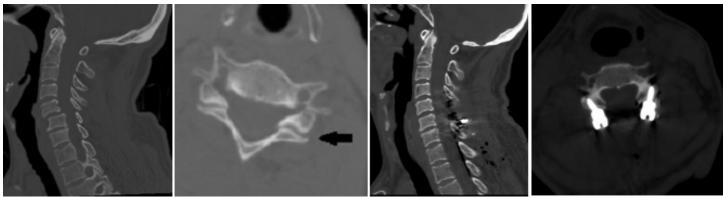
58-year-old male patient C5-6 listesis and facet locking after a fall. CT image after posterior fixation and C5-C6 total laminectomy with C4-5-6-7 lateral mass.
